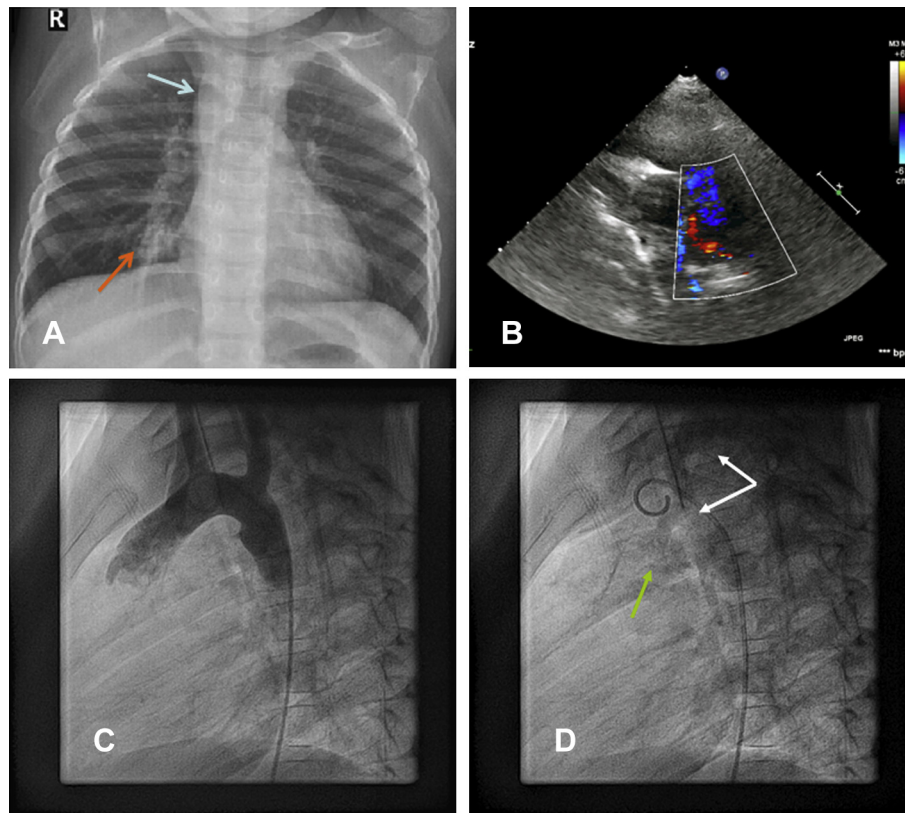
A – Chest X-ray in postero-anterior view shows pulmonary plethora (orange arrow) and right aortic arch (blue arrow) but no cardiomegaly with cardiothoracic ratio of 0.5. B – Transthoracic echocardiogram in parasternal short axis view shows continuous flow in pulmonary artery seen at the origin of left pulmonary artery. C – Aortic arch angiogram in left lateral view shows there is no evidence of patent ductus arteriosus. D – Aortic arch angiogram in dead lateral view shows filling of pulmonary artery (green arrow) from left vertebral and subclavian artery (white arrow).
